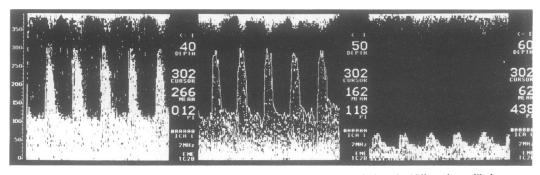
Typical transcranial Doppler sonographic finding in ICA dissection. Left and middle: submandibular insonation reveals high flow velocities (266 and 162 cm/s) at 40 and 50 mm insonation depths, indicating high grade stenosis. Right: poststenotic low flow (62 cm/s) at 60 mm depth.
